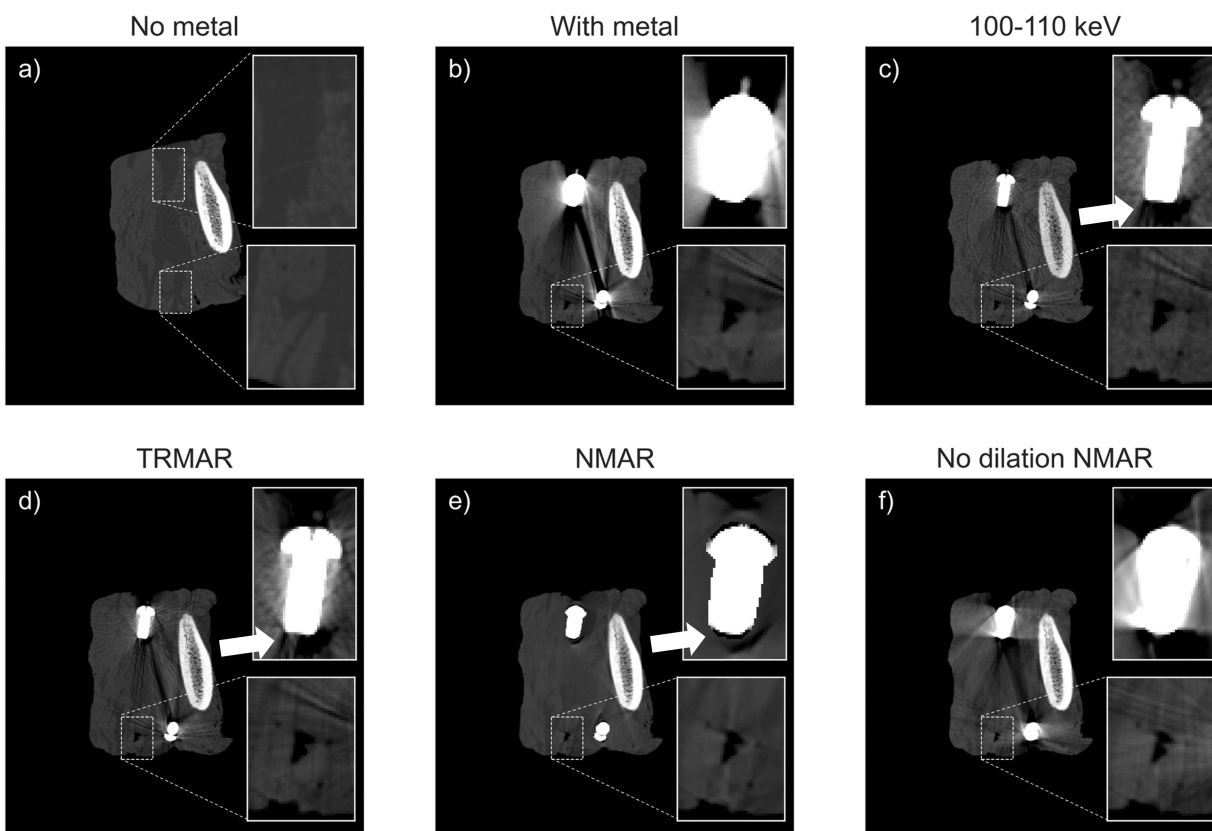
CT images of a beef short rib in a) the 30-120 keV bin no embedded, b) the 30-120 keV bin with uncorrected metal, c) the 100-110 keV bin with metal, d) the 30-120 keV bin corrected using TRMAR, e) the 30-120 keV bin corrected using NMAR, and f) the 30-120 keV bin corrected using NMAR with no dilation applied to the segmented metal. Inserts in b-f) show closeups of the two screws. $W/L = [1800/500 \text{ HU}]$.
